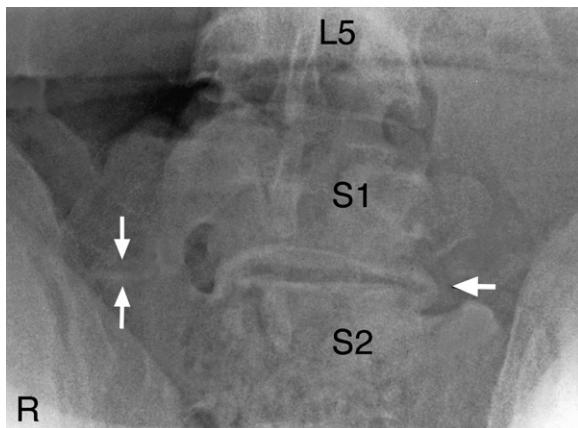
Lumbosacral erect posture anteroposterior plain X-ray image. Note (i) the right sided lumbarization of S1, (ii) the partial fusion of the right transverse process of S1 with the sacral ala (white arrows), and (iii) the left sided osteophytes (white arrow) bridging across the S1–2 vestigial intervertebral disc space.
